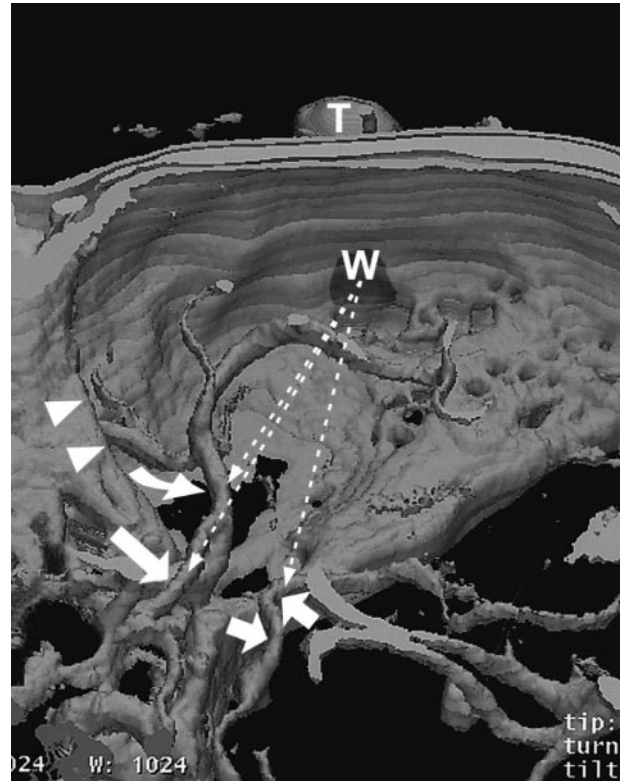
Three-dimensional CT reconstruction shows course of ultrasound beam (dashed arrows) toward middle (curved arrow), anterior (long straight arrow), and posterior (short straight arrows) cerebral arteries. Note resultant sites of vessel intersection with ultrasound beam and angle of insonation, as well as relationship of arteries to lesser sphenoid wing (arrowheads), acoustic window (W), and transducer. T = transducer. Reproduced with permission from Krejza et al.²⁴
